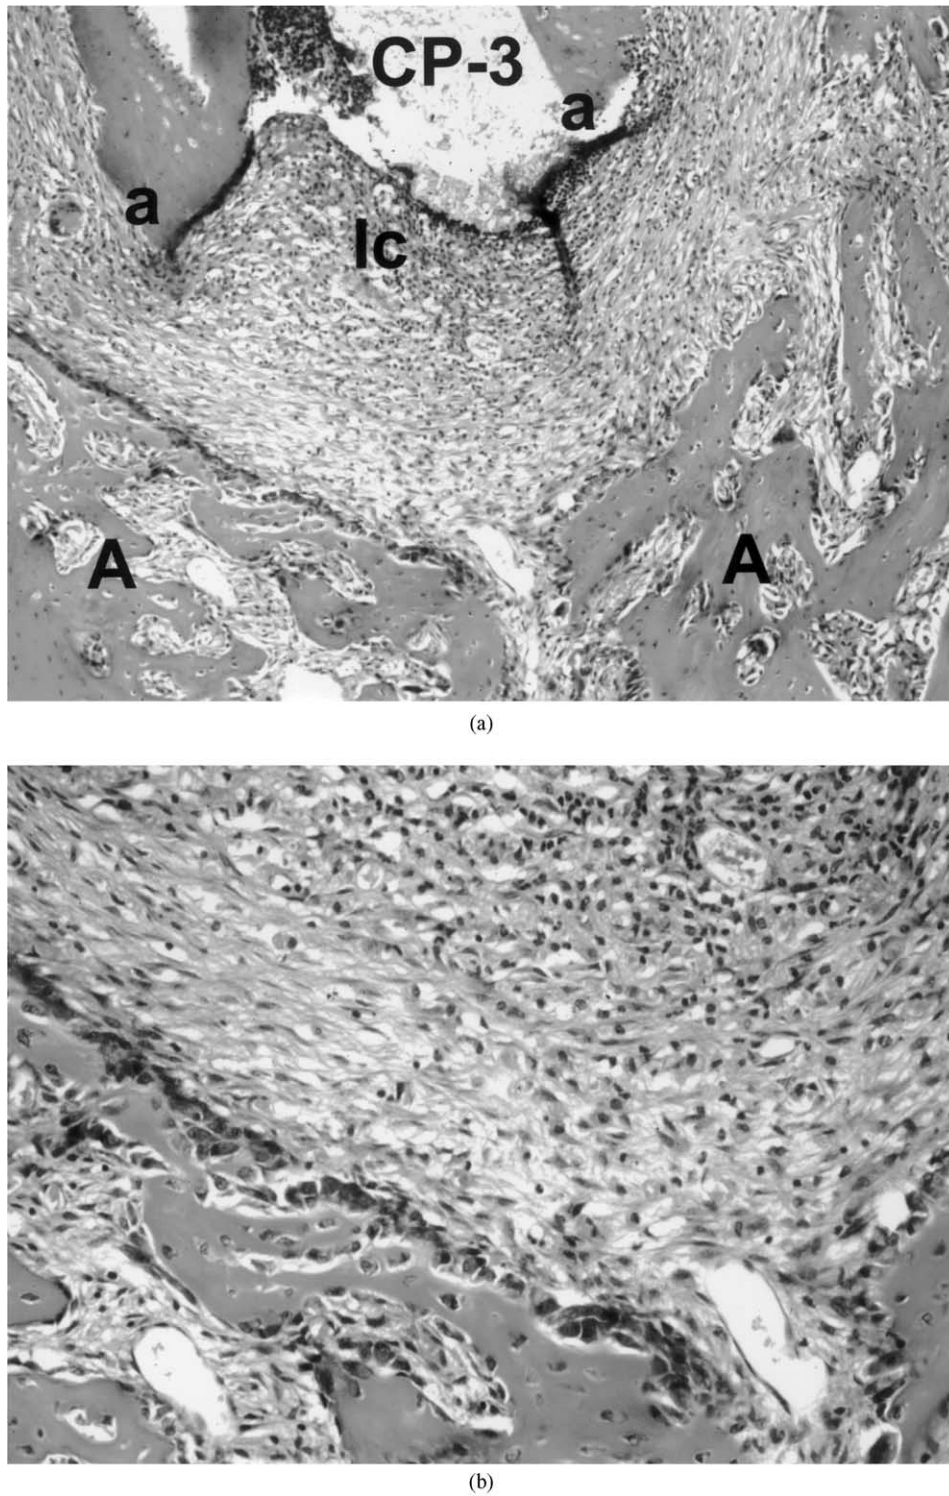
(a) Two weeks after placement of CP-3 in the apical root canal. There was no inflammatory response in the periapical area. Many cells were arranged on the margin of periapical alveolar bone. CP-3: Calcium phosphate cement filled in the root canal; Ic: Inflammatory cells; a: Apex; A: Alveolar bone (Orig. Mag.  $\times 20.0$ ). (b) Higher magnification of (a). Polarized cells arranged on the margin of periapical alveolar bone were observed. (Orig. Mag.  $\times 50.0$ ). (c) Four weeks after placement of CP-3 in the apical root canal. Periapical alveolar bone appeared nearly normal. D: Dentin; a: Apex; A: Alveolar bone; C: Cementum (Orig. Mag.  $\times 20.0$ ).
